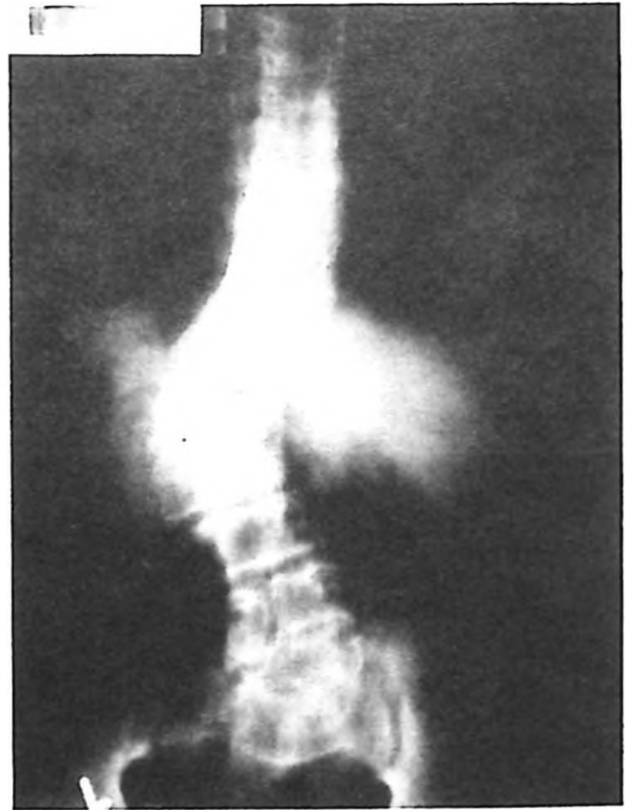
Anteroposterior radiograph of the spine showing scoliosis, platyspondyly and narrow intervertebral spaces.
